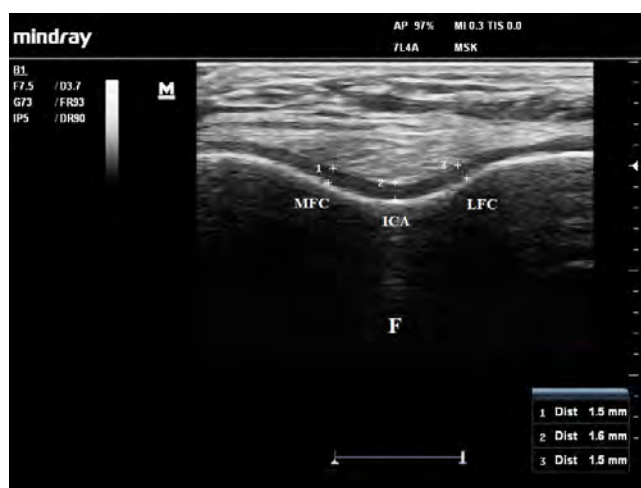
Ultrasonographic image demonstrating the sites of femoral cartilage thickness measurements (F: Femur, ICA: Intercondylar area, LFC: Lateral femoral condyle, MFC: Medial femoral condyle)
